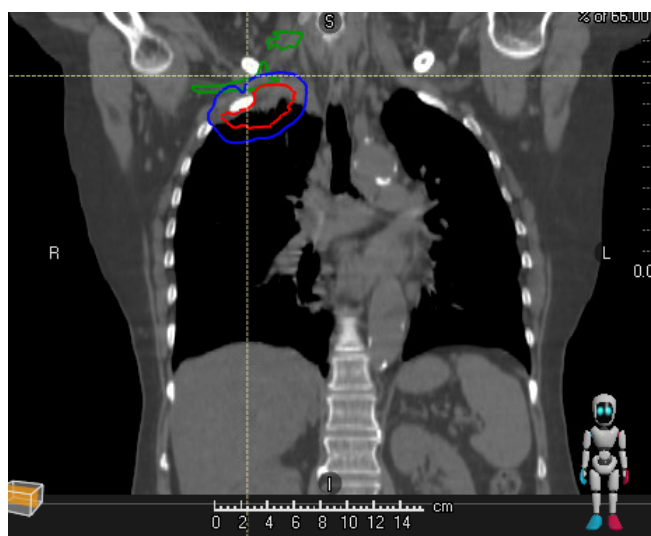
CT 1 image for patient 16 showing brachial plexus (green) in close vicinity to the ICTVu (red) and PTVu (blue).
